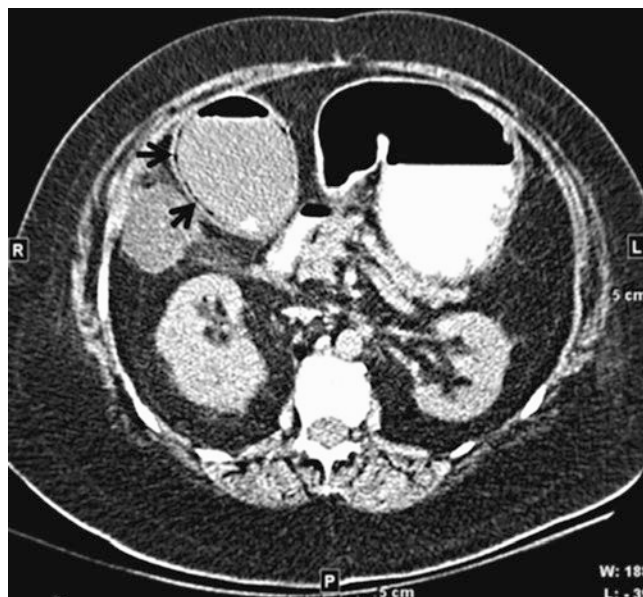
Axial CT showing air in the gallbladder wall, known as emphysematous cholecystitis
